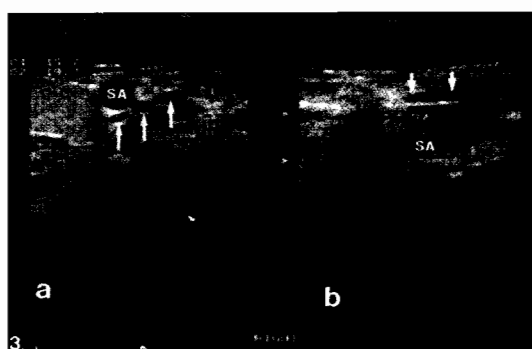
Sonographic appearances of the trunks of the brachial plexus (arrows). SA: Subclavian artery.
